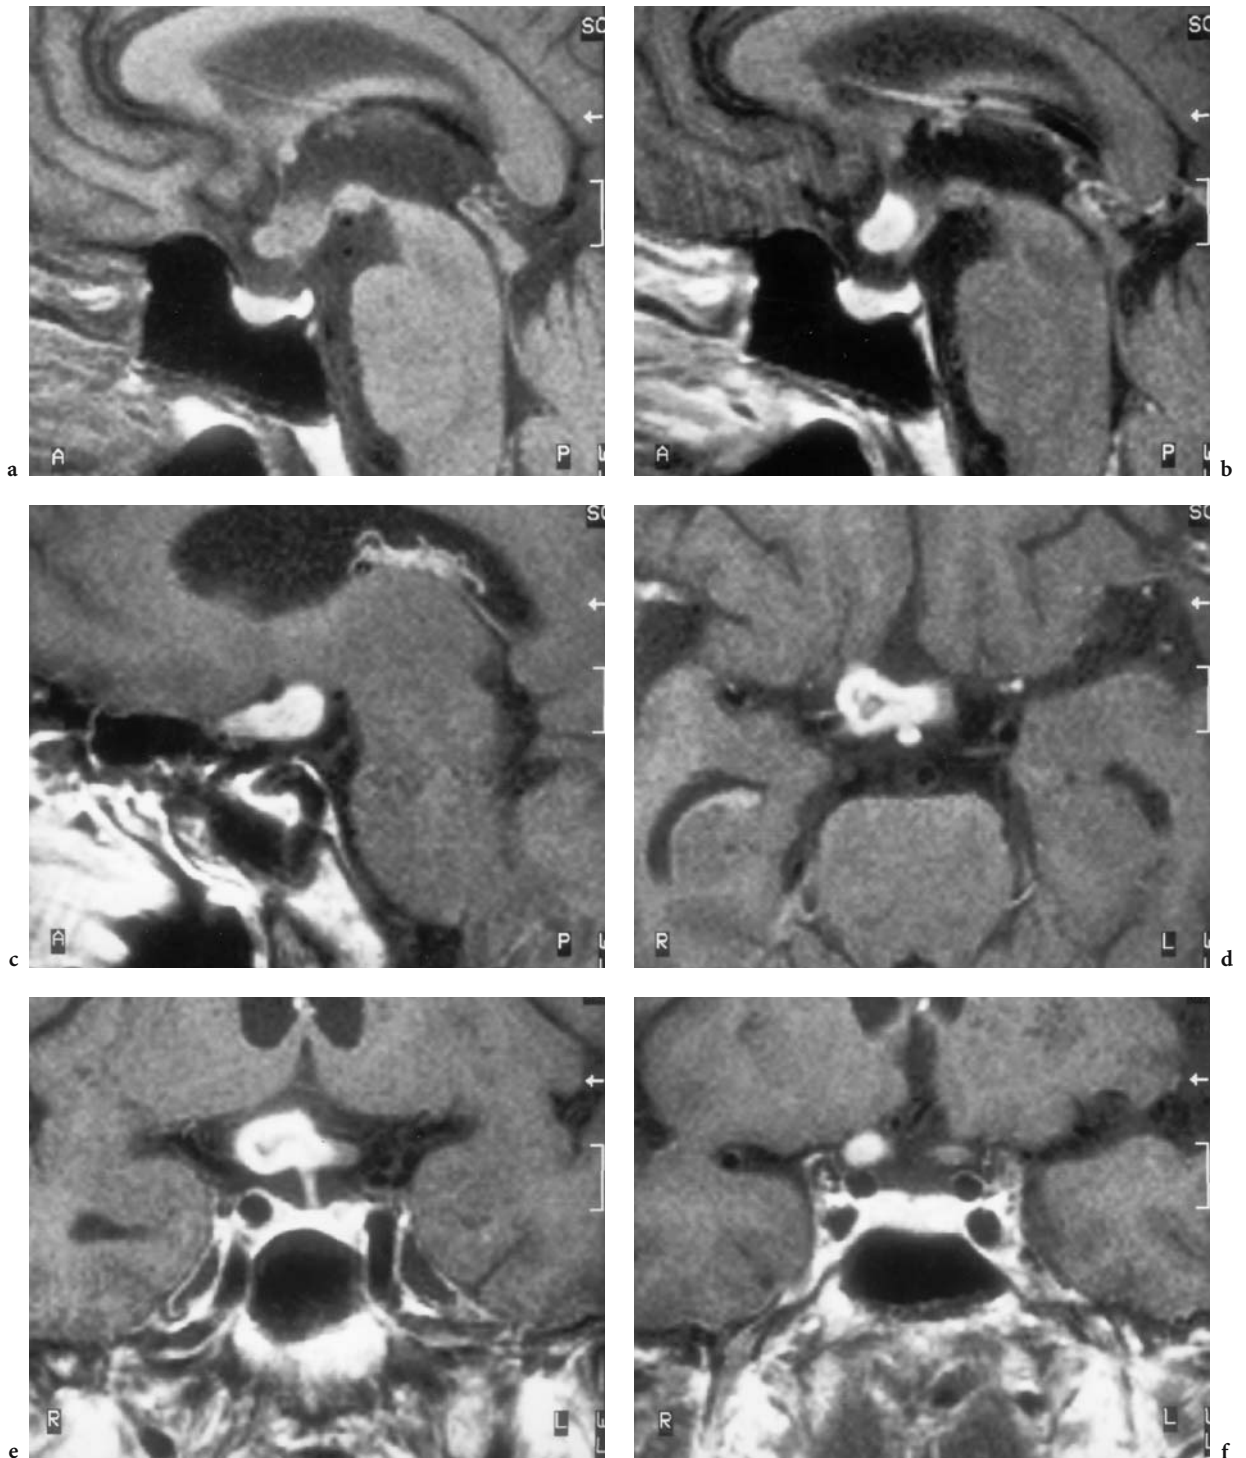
A 70-year-old woman with a visual deficit progressing to complete loss of vision in the right eye within 2 weeks, and subsequent loss of vision (0.1) in the left eye. Diagnosis: glioblastoma of the chiasm, intracranial optic nerve, and proximal optic tract. MRI: a Midsagittal T1-weighted native image with diffuse enlargement of the chiasm and hypothalamus. b Corresponding T1-weighted, contrast-enhanced image with brighter signal enhancement of the enlarged chiasm than of the pituitary stalk. c Right paramedian sagittal, T1-weighted, contrast-enhanced image showing tumor expansion along the proximal optic tract. d Axial, T1-weighted, contrast-enhanced view, demonstrating lateralization of the tumor growth to the right, as well as some necrosis at the center of the tumor. e Coronal, T1-weighted, contrast-enhanced image visualizing exclusive infiltration of the chiasm. f Coronal, T1-weighted, contrast-enhanced view, several millimeters anterior to e with tumor infiltration of the intracranial right optic nerve
